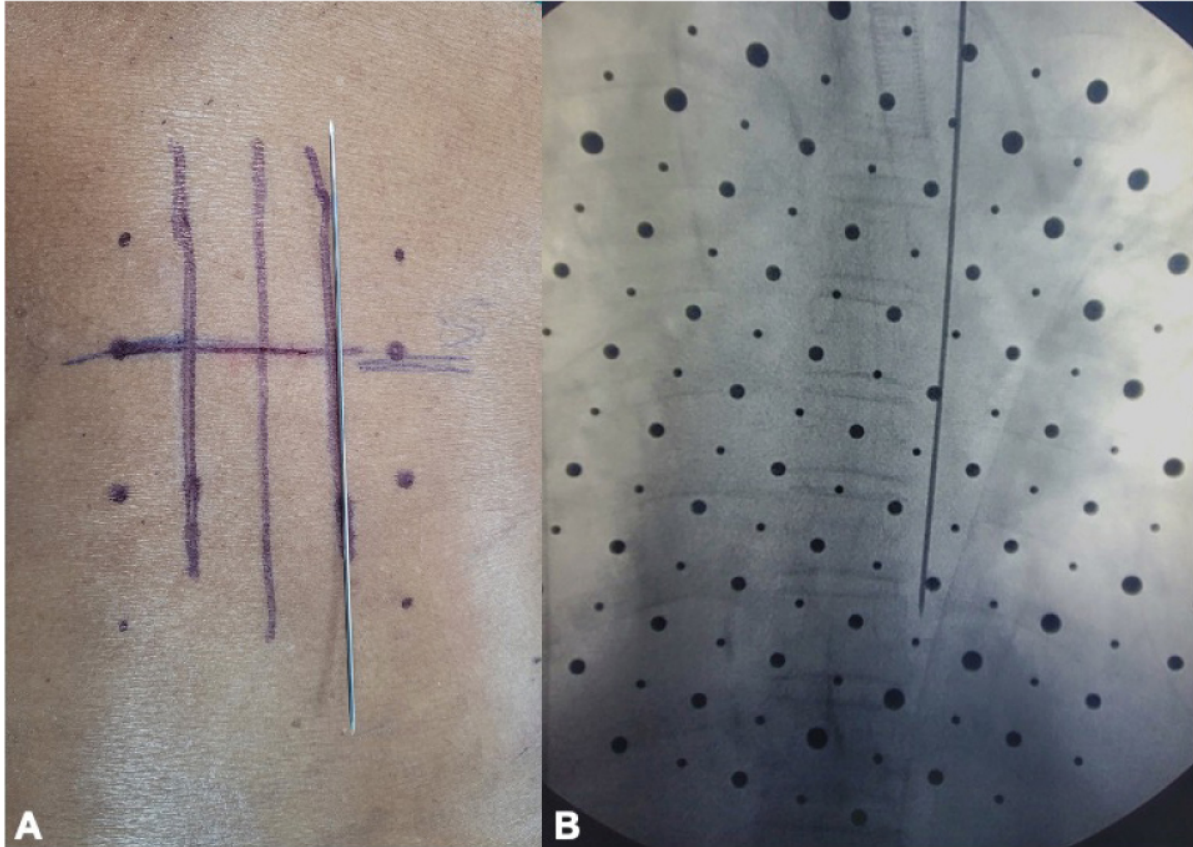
(A) A skin incision is marked by using a K wire parallel to midline. This skin incision is based on the AP X-ray where the incision is about 0.5°cm lateral to the lateral edge of the pedicle (B).
